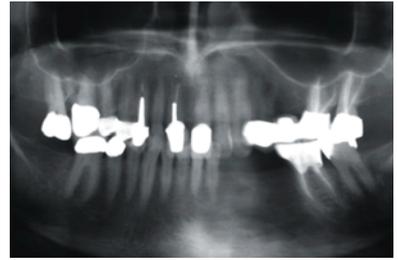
Case 2. Preoperative radiograph of patient, who desired a conservative treatment for missing teeth #27 through #29.
